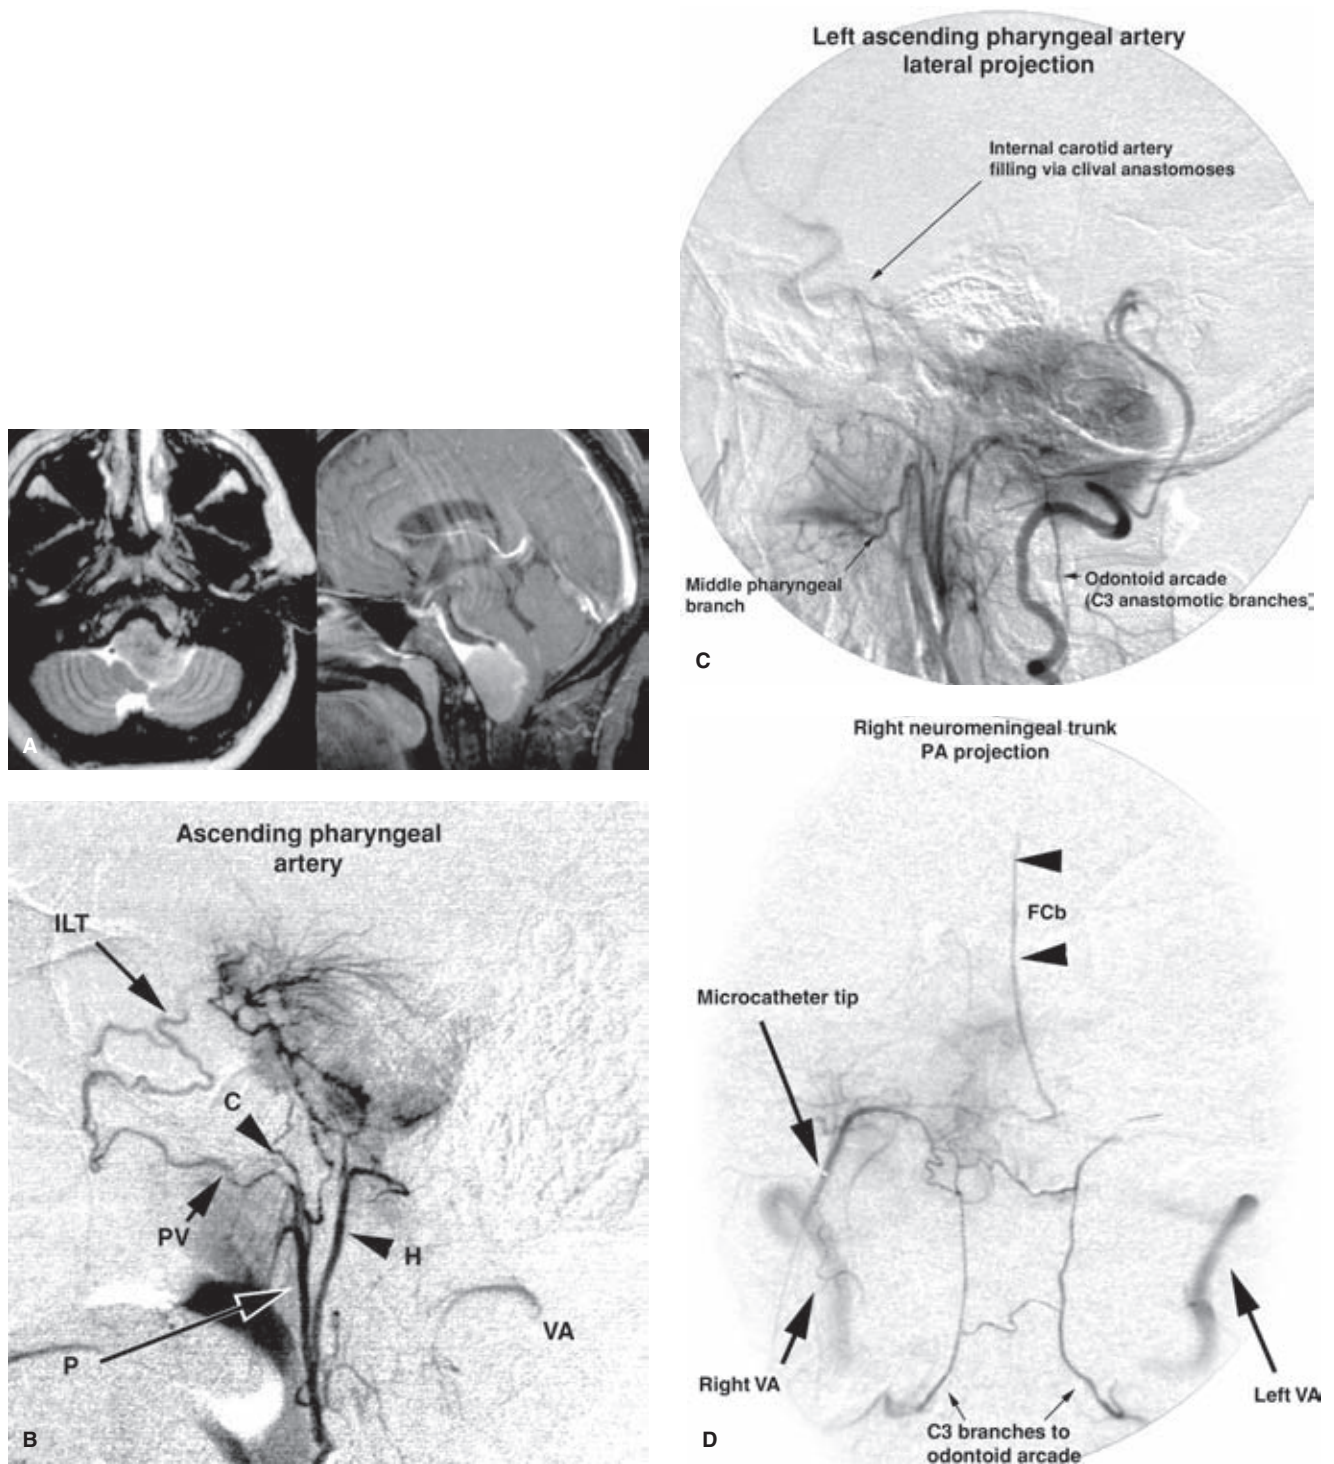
(A–B) Ascending pharyngeal artery. A: Axial T2-weighted and sagittal T1-weighted (fat-saturation postgadolinium) MRI images demonstrate a typical appearance of a near midline clival meningioma. There is pronounced deformity of the structures of the posterior fossa. A dural tail of enhancement extends up to the dorsum sellae. B: A microcatheter injection of the right ascending pharyngeal artery, lateral projection, demonstrates a pronounced tumor blush corresponding with the sagittal appearance of the tumor. The pharyngeal trunk (*P*) and hypoglossal branch (*H*) of the neuromeningeal trunk are well seen. The superior pharyngeal branch of the pharyngeal trunk anastomoses to the territory of the internal maxillary artery via the pterygoglossal artery (*PV*). This results in opacification of the inferolateral trunk (*ILT*) via the artery of the foramen rotundum. The superior pharyngeal artery may also connect with the middle cranial fossa via the foramen lacerum through its carotid branch (*C*). The vertebral artery (*VA*) is transiently opacified on this injection. (C–E) C: A lateral projection of the left ascending pharyngeal artery injection demonstrates a tumor blush with a tail extending to the dorsum sellae. Faint opacification of the internal carotid artery is seen, probably through clival anastomoses. The left vertebral artery is compressed by the tumor and shows slow runoff. It is opacified by the odontoid arcade from the neuromeningeal trunk. D and E: A selective PA injection (D) and lateral view (E) of an injection in the neuromeningeal trunk of the right ascending pharyngeal artery demonstrates the odontoid arcade and its anastomoses across the midline. Both vertebral arteries are opacified by this injection through the C3 branches. A midline artery extends high above the sella on this view; therefore, it represents the artery of the falx cerebelli (*FCb*).
